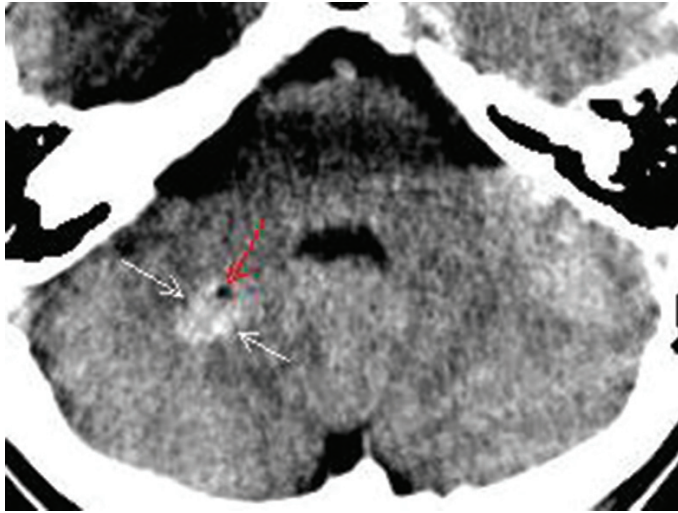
The axial unenhanced CT scan shows a hyperdense lesion in the right cerebellar hemisphere (white arrows) with round, hypodense area in the anterior aspect of lesion (red arrow)
